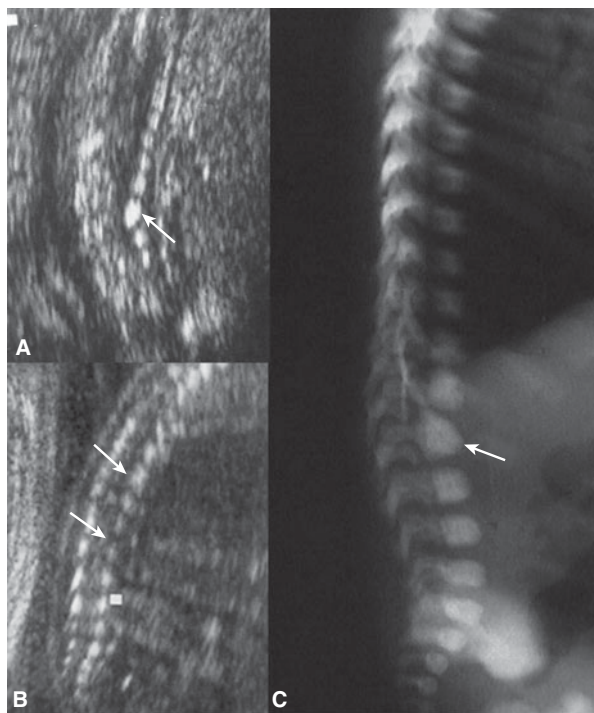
Hemivertebra diagnosed at 15 postmenstrual weeks (arrow in A), with improvement of scoliosis at 23 postmenstrual weeks (arrows in B). Normal clinical examination after delivery but a non-segmented, fused vertebra was diagnosed by radiograph (arrow in C). (Courtesy of Bronshtein Moshe, MD, Haifa, Israel.)
